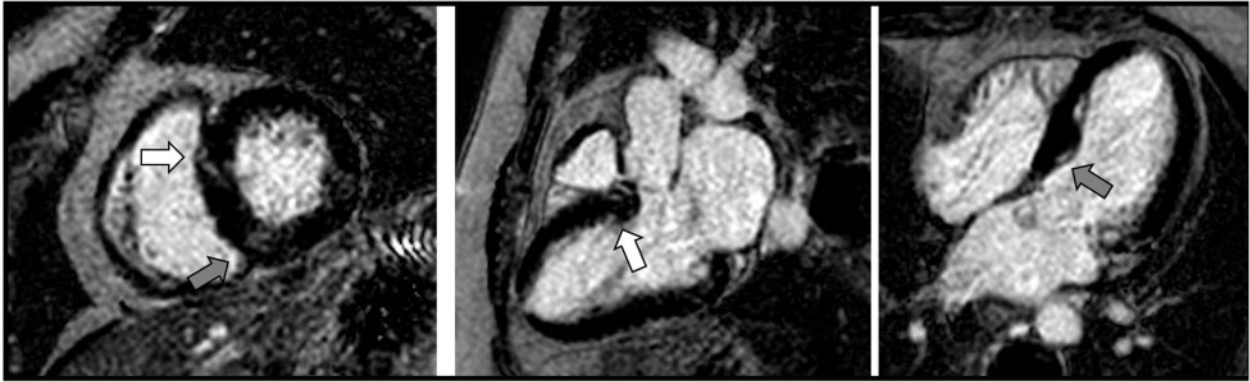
Cardiac magnetic resonance imaging. Delayed gadolinium enhancement imaging of the left ventricle from basal short axis, three-chamber (left ventricular outflow tract) and four-chamber views. Mild, patchy, mid-myocardial delayed enhancement is demonstrated in the anterior (white arrows) and inferior (grey arrows) segments of the basal inter-ventricular septum.
